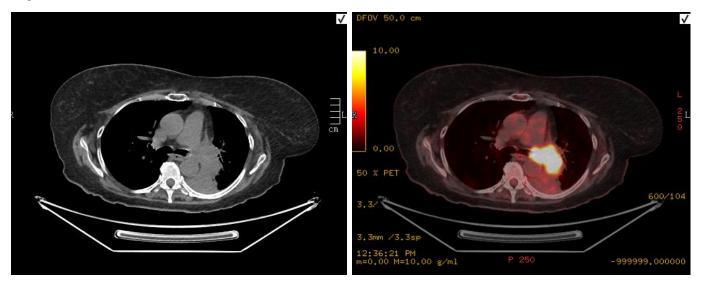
REGISTRATION OF CT AND PET IMAGES.
